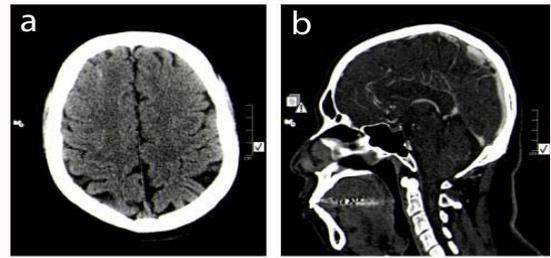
(a) Unenhanced CT head demonstrates subtle right frontal lobe subarachnoid hemorrhage. (b) Sagittal MPR from a code stroke CTA shows a filling defect in the SSS.
